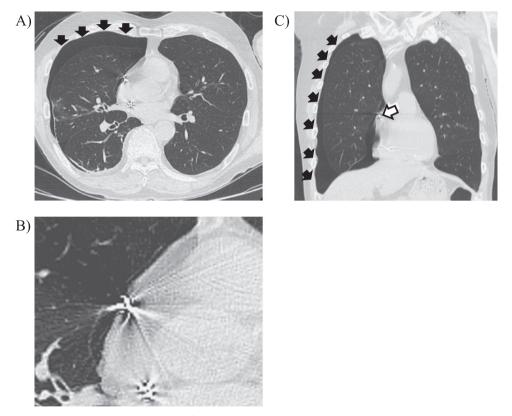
Chest radiographic computed tomography (CT) image 4 days after pacemaker implantation. A) Axial CT image showing the right-sided pneumothorax (solid arrows). B) Axial CT image showing the atrial lead perforation through the right atrial wall. C) Coronal CT image showing the right-sided pneumothorax (solid arrows) and atrial lead perforation through the right atrial wall (open arrows).
